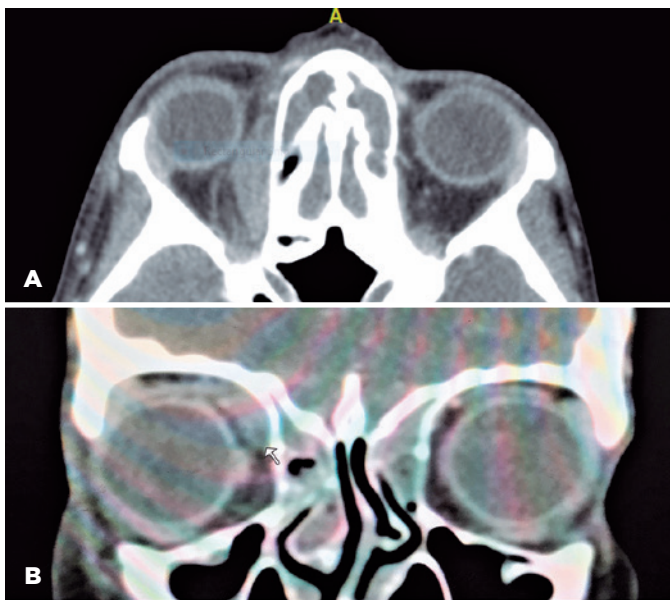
CT scan of the orbits upon admission. A) Axial superior orbital cut shows enlarged superior oblique myositis mimicking a subperiosteal abscess, B) The coronal orbital cut shows the superomedial soft tissue density with ethmoidal sinusitis.
